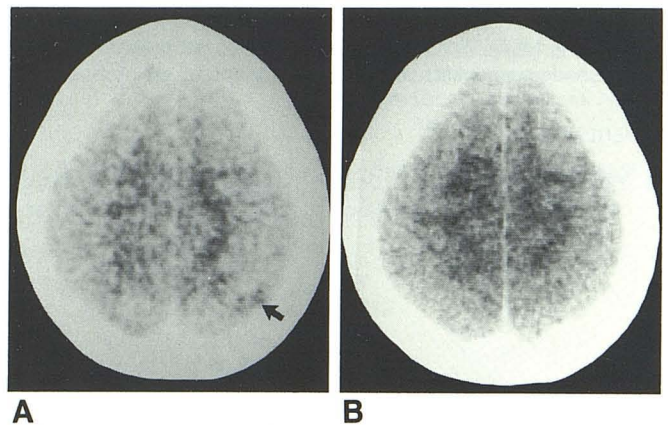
Case 1: Preeclampsia. A, Initial CT scan. High parietal, cortical low-density zone in superior parietal lobule on left (*arrow*). This lesion did not enhance. There were other, smaller low-density foci on left side in a more rostral cut. No CT abnormality was discernible in regions of visual pathways or visual cortex, however. B, Same level as A, 5 weeks later. Low-density zone in superior parietal lobule has reverted to normal, as did the more rostral abnormalities.
